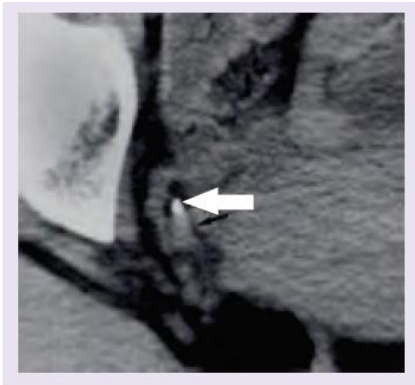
CT of the kidneys, ureters and bladder shows a classic comet tail sign in a phlebolith (arrow) at the right pelvic side wall.
